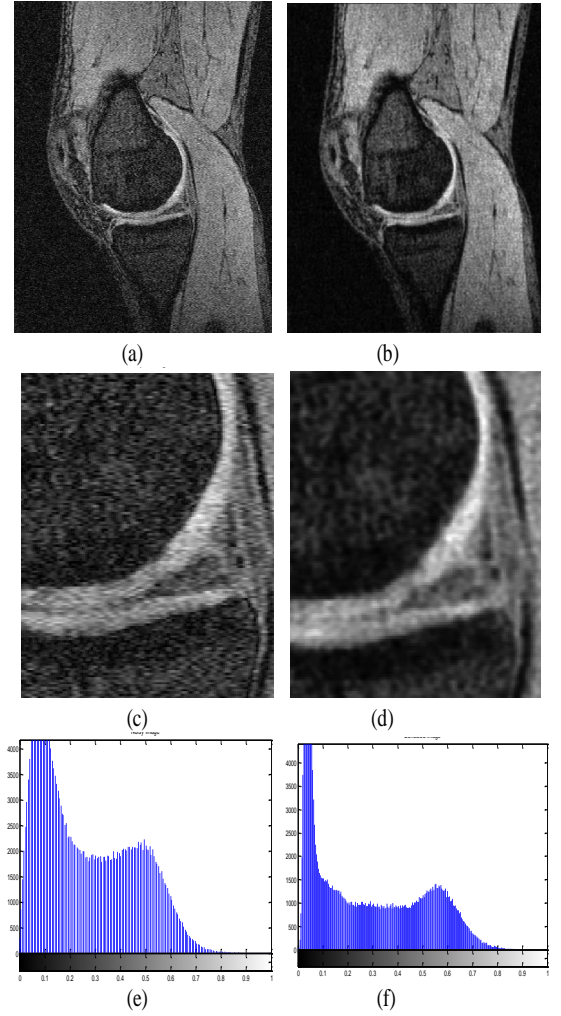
a) Noisy MRI image of articular cartilage, slice 16 of MRI dataset b) Denoised cartilage image c) magnified image of cartilage tissue d) magnified image of denoised cartilage tissue e) histogram of noisy image and f) histogram of filtered image
